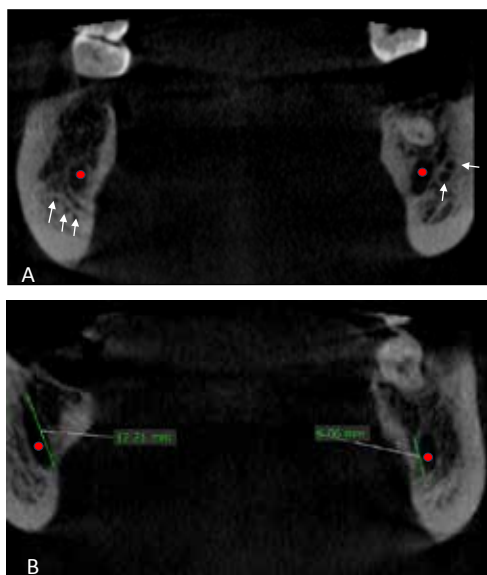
Coronal section of the cbct scan with posterior to anterior orientation. A showing multiple accessory canals (white arrows) inferior and lateral to the main mandibular canal (red dots) bilaterally, an isolated canal & foramen exiting on the medial aspect of the mandible (yellow arrow). B showing the right sided canal measuring 6.86mm and left sided measuring 12.21mm vertically at the level of the second molar.
